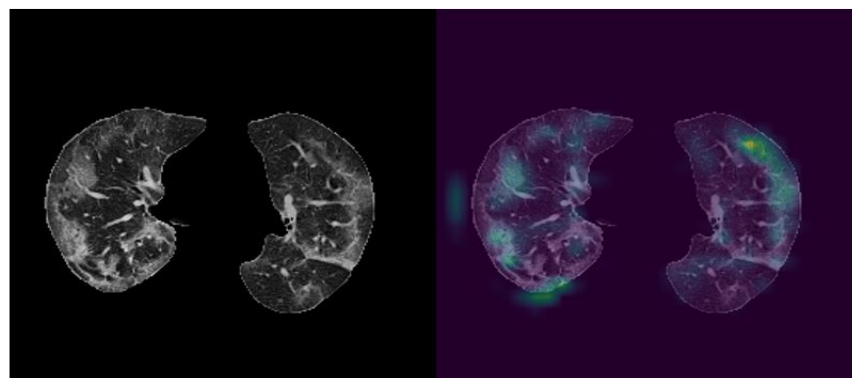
Visualization of CNN outputs. Left: Cropped CT image, right: visualized feature map of CNN output. The right image shows CNN blocks are capable of capturing Ground Glass Opacities in CT images.
